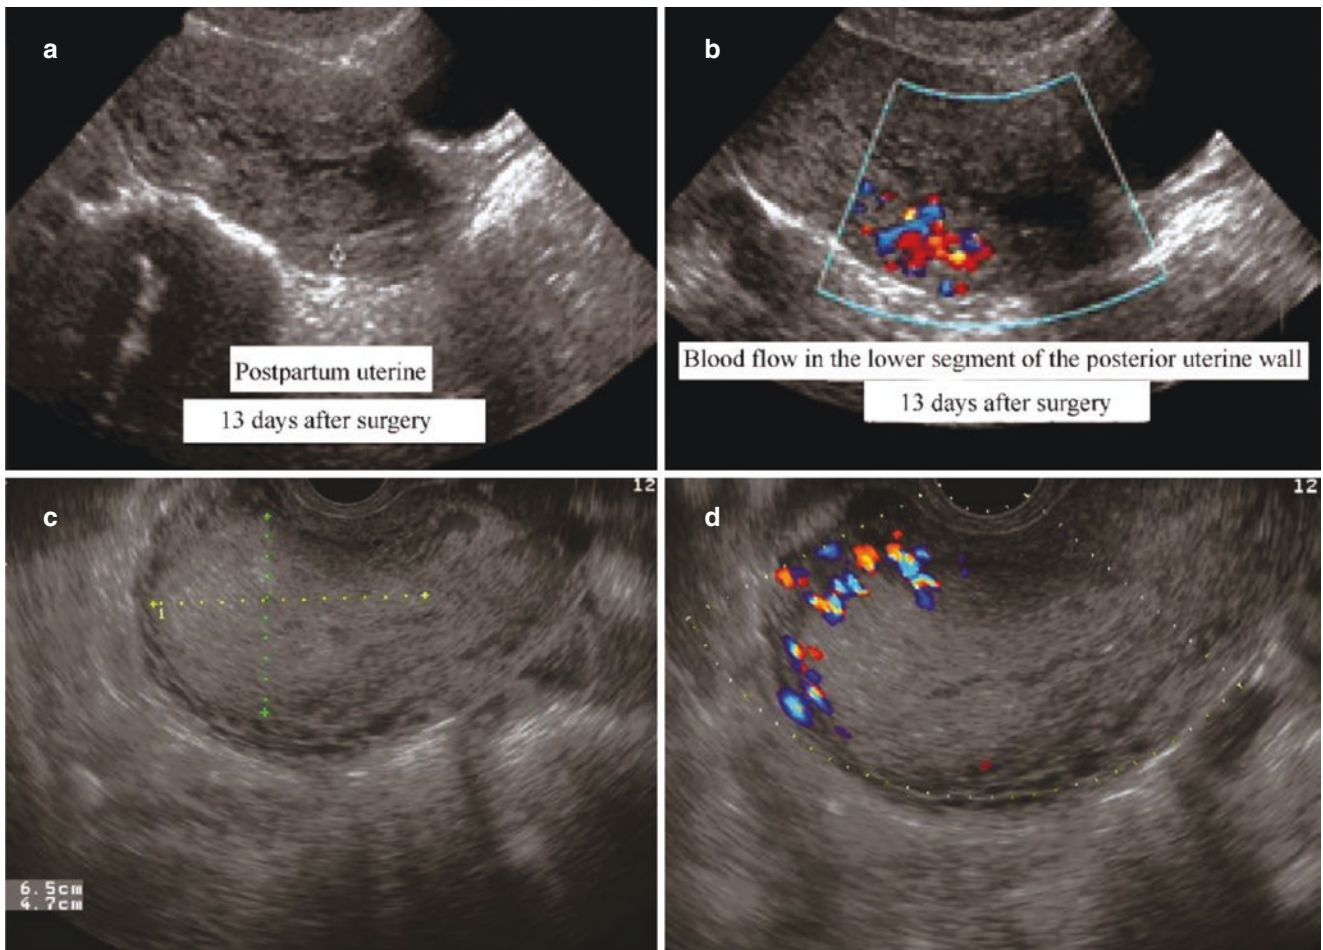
Postpartum partial placenta implantation. (a, b). The patient is diagnosed with placenta implantation by ultrasound before the operation and confirmed by cesarean section. After 2 weeks of fetal preservation treatment, a mass in the lower segment of the posterior uterine wall is shown, with surrounding blood flow; (c, d). Incomplete
